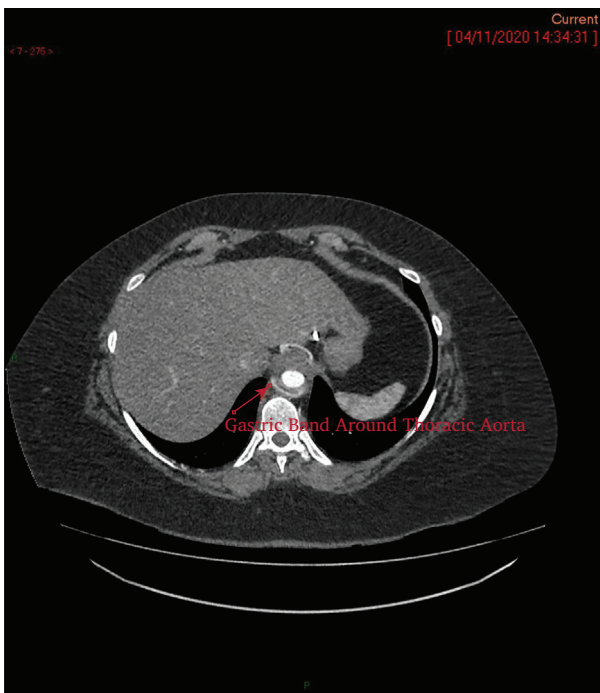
Axial slice computed tomography showing gastric band around the aorta at level of T12.
